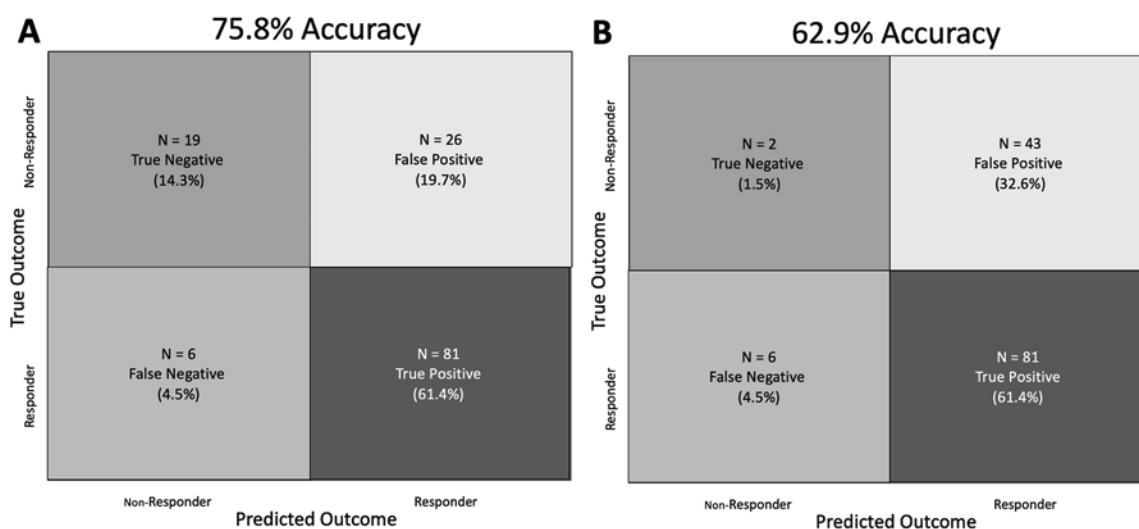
Prediction of response using machine learning. A: Extracted GMV from the right posterior parietal cortex and SMA, along with age and callosal angle, was fed into an SVM model and validated with LOOCV. B: The comparison model used demographic data and conventional MRI measurements. Figure is available in color online only.
